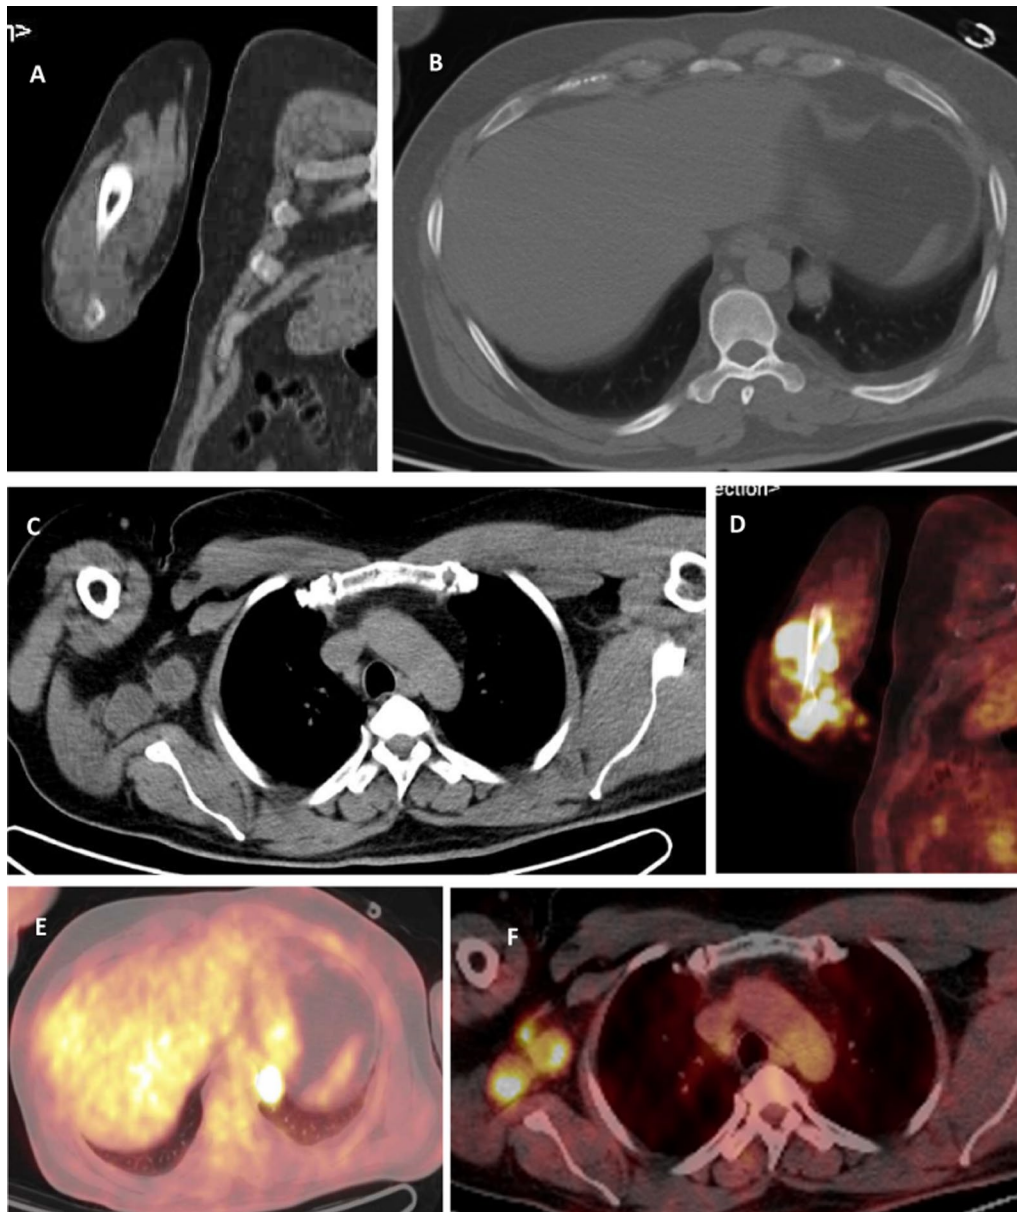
A 38 years old male patient with biopsy-proven right distal humerus chondrosarcoma. Tumoral excision was done, and the patient was referred for post-operative assessment of any residual tumors. A, B, C Axial CT images and D, E, F Axial fused PET/CT images show extensive FDG uptake at right elbow at the operative bed infiltrating the surrounding muscles with SUVmax ~ 18.2 associated with multiple right axillary and mediastinal retrocaval lymphadenopathy with corresponding increased FDG uptake (SUVmax ~ 12.9 and 3.5 respectively) as well as metabolically active left lung basal deposit with SUVmax ~ 16.3 denoting local tumoral residue/recurrence, locoregional lymph nodes and distant metastases. Twenty months later, the patient was referred again after total right upper limb amputation for follow-up and detecting any viable tumors. G Coronal CT, and H Coronal fused PET/CT images show significant progression in size, number and metabolic activity of the pulmonary nodular deposits and mediastinal lymphadenopathy with SUVmax reaching up to 18.2 and 9.1 respectively
